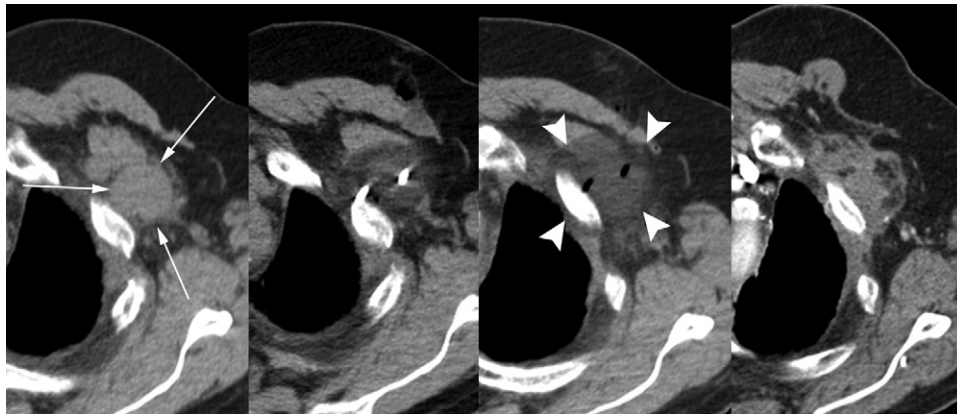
Images from a 68-year-old man with metastatic adenocarcinoma who received localized radiation treatment to the chest and had discontinued erlotinib because of diffuse skin eruptions. He presented with a left chest wall metastatic lesion abutting the second rib near the site of a previous thoracotomy for a left lung mass 1 year earlier. Images (from left to right) show the preoperative, intraprocedural, immediate postablation, and 2-year follow-up enhanced axial CT appearance of the mass. Initial measurements were $5.1 \times 3.2 \times 4.0$ cm (image 1, arrows), and the mass resorbed into a diffusely hypovascular mass measuring $3.8 \times 2.2 \times 2.0$ cm approximately 22 months later. A well demarcated hypodense ablation zone (image 3, arrowheads) is shown on immediate postablation axial CT.
